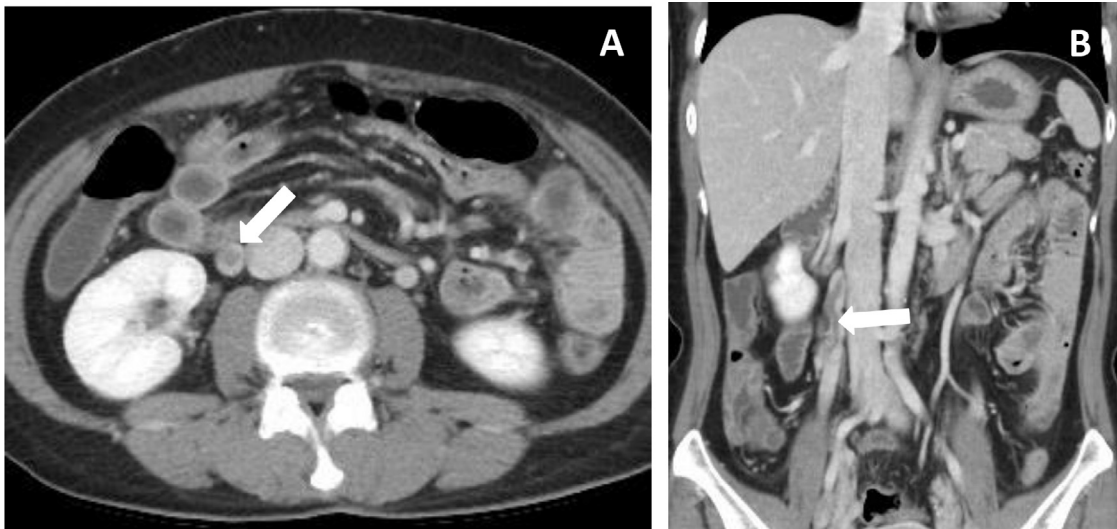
Axial (A) and coronal (B) intravenous contrast-enhanced computed tomography images of the abdomen and pelvis showing thrombosis of the right ovarian vein (white arrow).
